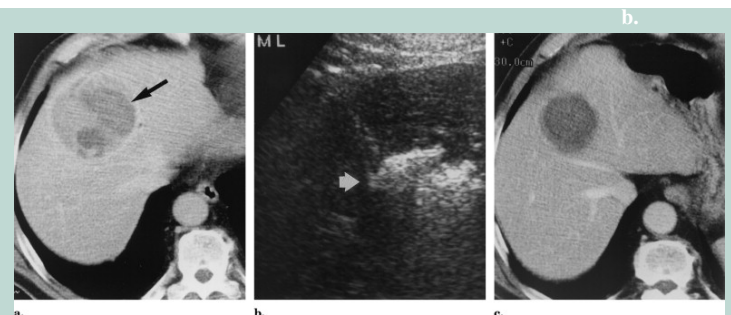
(a) Preprocedural HCC (dark arrow) within the right lobe of the liver with mixed enhancement and density. (b) Intraprocedural ultrasound image with probe placed within the lesion. Echogenic nitrogen bubbles (white arrow) develop within the lesion. (c) 3 month follow-up CT demonstrates lack of enhancement, uniform low density, and decreasing size.
